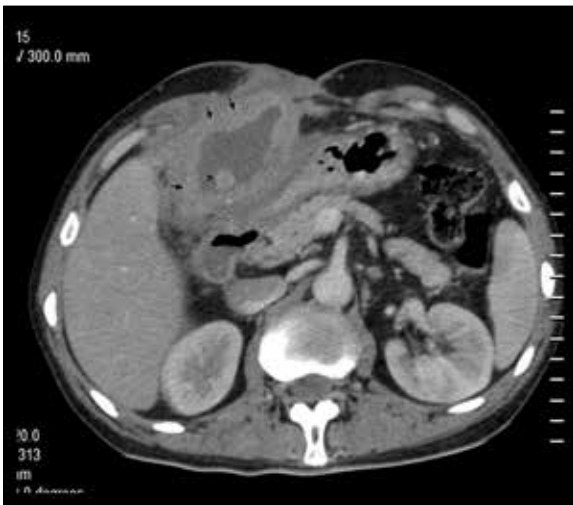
Contrast-enhanced axial CT showing the fundus of GB reaching up to the anterior abdominal wall. There is marked thickening of the GB wall (arrows). A calculus is also seen in the lumen of GB (arrow head).
